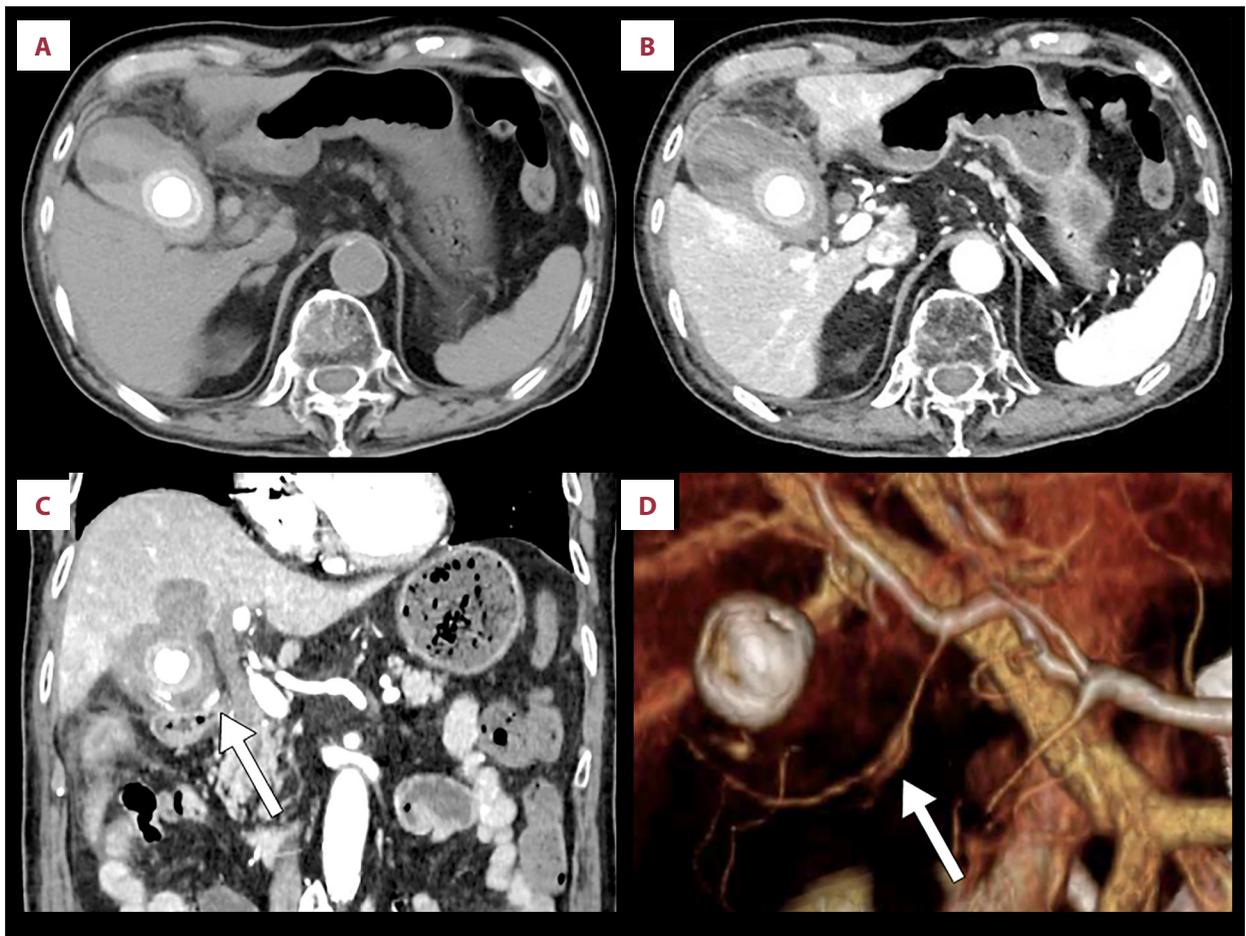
Preoperative computed tomography (CT) findings. (A) A gallstone measuring 29 mm in diameter is present in the gallbladder. The lumen of the gallbladder and the common bile duct (CBD) are shown as high-density areas. (B, C) Contrast-enhanced computed tomography (CT) images show extensive inflammation of the fat (fat necrosis) surrounding the gallbladder and the area of spread of the hematoma into the liver bed (B axial scan; C coronal scan). An 8mm nodular lesion is also shown on the cystic artery. (D) Three-dimensional (3-D) CT angiography confirmed the nodular lesion.
